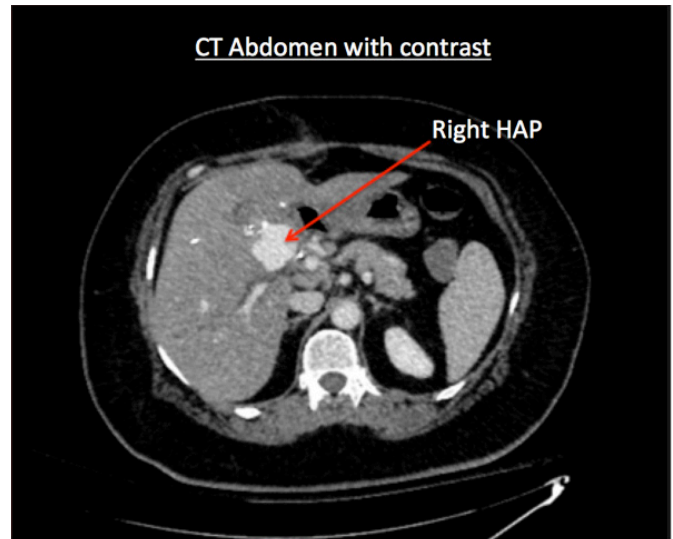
CT demonstrating evidence of right HAP.
